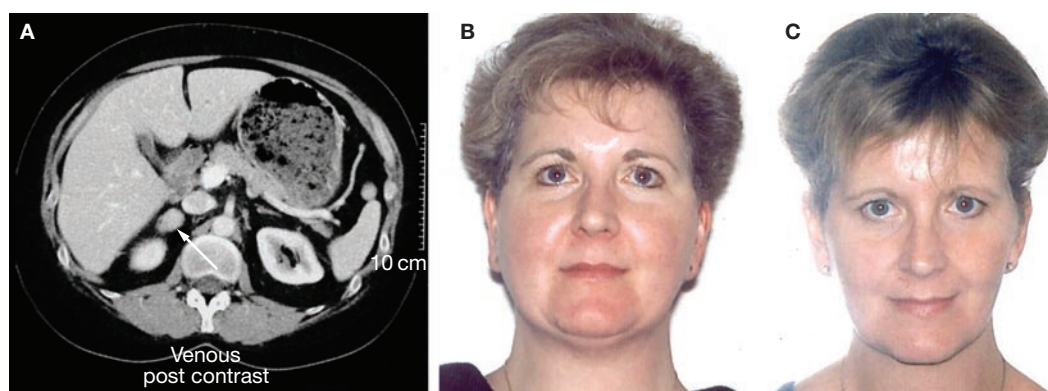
Abdominal CT scan and patient's appearance. (A) Abdominal CT from the patient showing a right adrenocortical adenoma (arrow). The same patient is shown (B) 1 month before and (C) 6 months after laparoscopic right adrenalectomy. Permission obtained from Blackwell Publishing © Holt RIG and Hanley NA (2006) *Essential Endocrinology & Diabetes*, edn 5.
